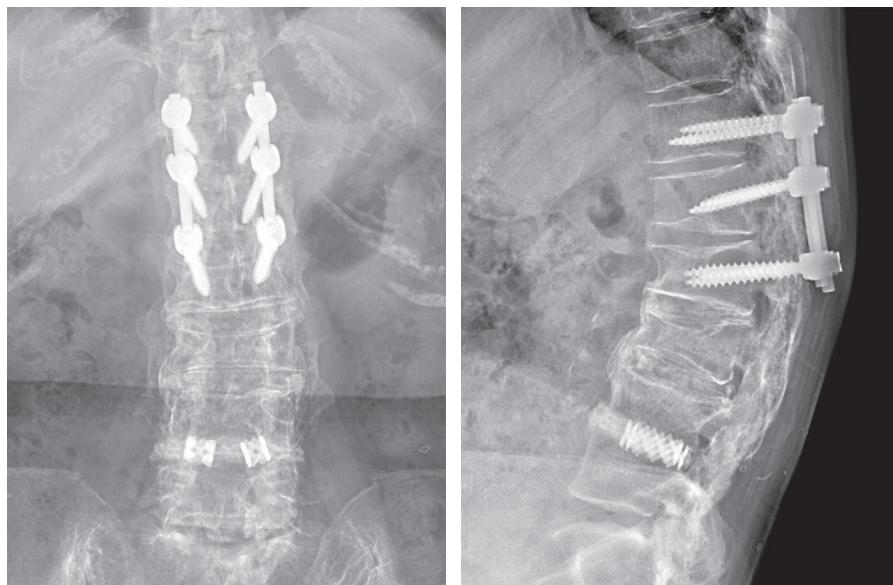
(Left) Lumbar anteroposterior and (Right) lateral radiographs at 3 years after surgery. The collapse of the L2–L4 body had progressed.
